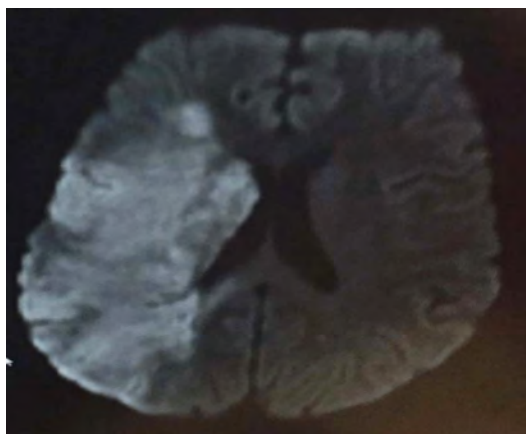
MRI Brain Scan showing large right cerebral infarct.
